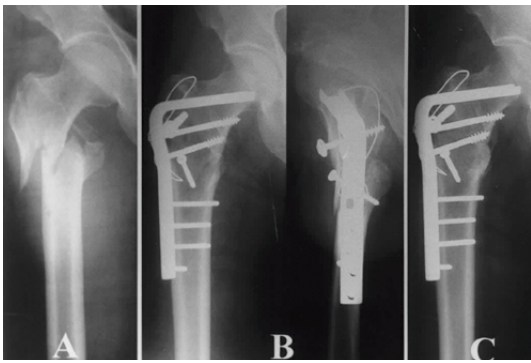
Initial radiograph shows intertrochanteric fracture of the femur with undisplaced fracture of the greater trochanter (AO type A3.1) in a 64-year-old man.
